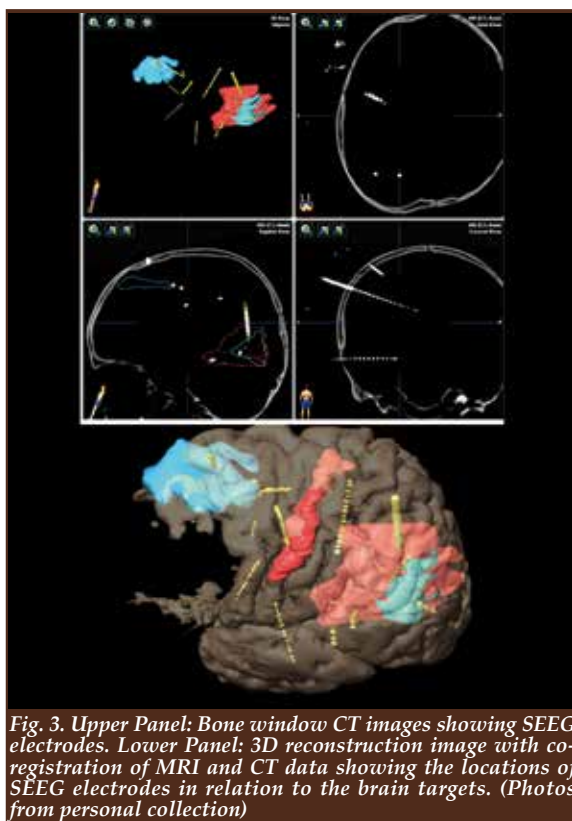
Upper Panel: Bone window CT images showing SEEG electrodes. Lower Panel: 3D reconstruction image with co-registration of MRI and CT data showing the locations of SEEG electrodes in relation to the brain targets. (Photos from personal collection)
